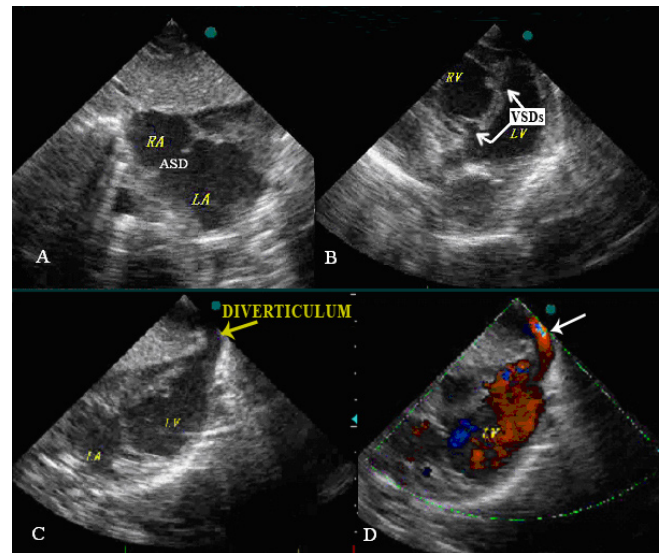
Two dimensional and color Doppler echocardiograms of the patient. A, large atrial septal defect (ASD) and relatively enlarged left atrium (LA) are seen in subcostal coronal view. B, two small muscular ventricular septal defect (VSDs) (arrows) are seen in apical five-chamber view. C, an apical outgrowth (diverticulum) is seen in modified four-chamber view (arrow). D, non-turbulent antegrade-retrograde flow is seen in the diverticulum by color Doppler imaging (arrow)
